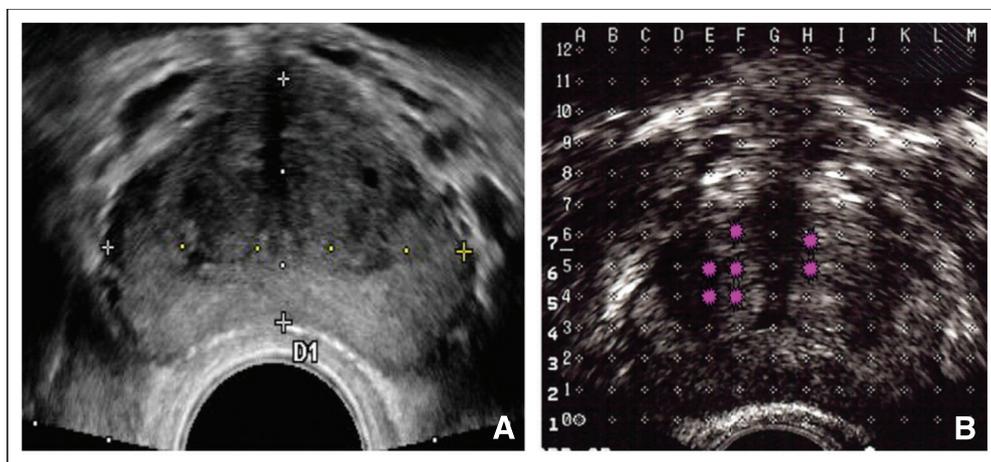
(A) Transrectal ultrasound (TRUS) in a 54-year-old patient. The ultrasound was normal. The patient had a TRUS biopsy, which revealed a 1-mm adenocarcinoma with a Gleason score of 6 on the right side of his gland. He underwent 1 year of watchful waiting and then had a three-dimensional prostate mapping biopsy (3D-PMB) for further staging. The ultrasound overshoots the anterior margin by 3 mm. (B) TRUS with a brachytherapy grid overlay. Where a grid dot overlays the prostate, a biopsy is taken. The starburst patterns in the anterior portion of both sides of his gland indicate where his 3D-PMB was positive for carcinoma with a Gleason score of 8. Obviously, this patient has to receive more definitive therapy.
